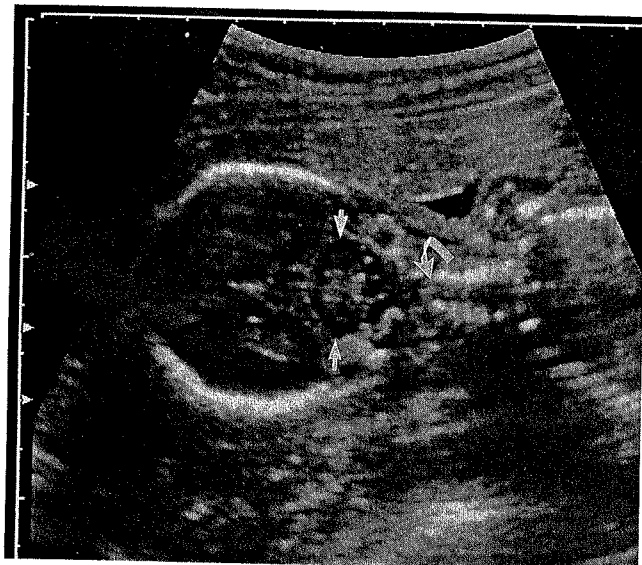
Sonographic view of transverse cerebellar diameter. Arrows indicate the points of measurement.
